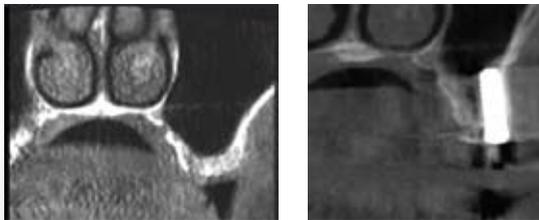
A and B. Comparison of CT scan between A (before) and B (after 3 months healing) at the site of # 16. New bone formation is evident with the CGF graft alone.
